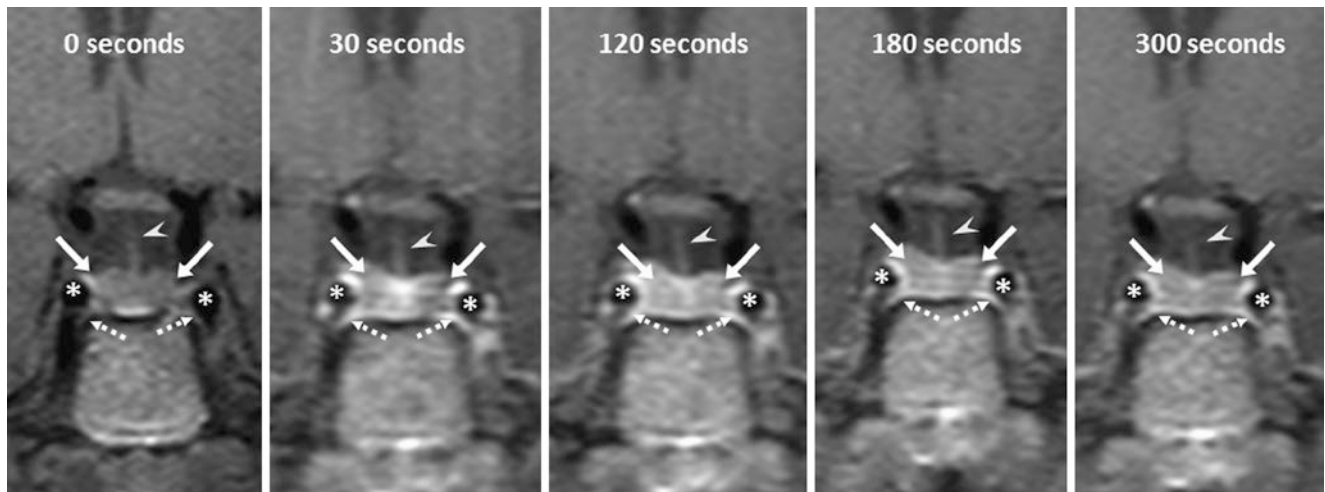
Normal pituitary dynamic enhancement extending laterally. The patient was a 27-year-old female with hyperprolactinemia. On a 3 T MRI (interpreted as normal), dynamic contrast enhanced T1WIs from time 0 s (noncontrast) to 300 s depict the lateral anterior lobes
